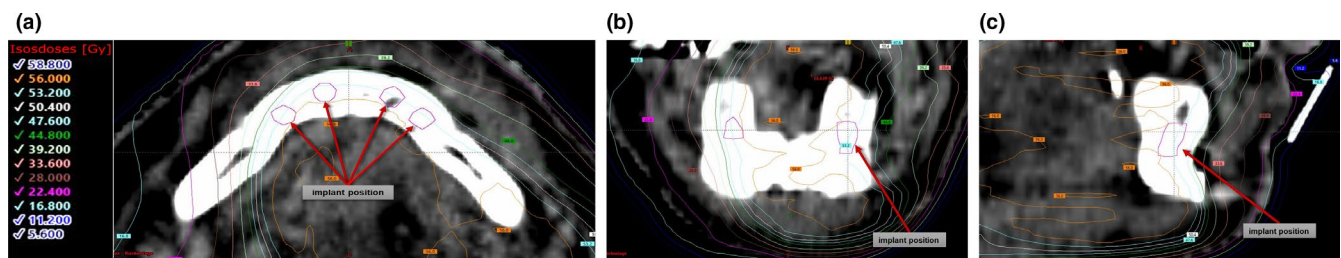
Radiotherapy (RT) planning CT data set matched to the position of the implants (outlined in pink and indicated by the red arrows). (a) Axial view with corresponding RT isodose lines in Gy (box to the left) in the color of their respective field line. (b) Coronal view with corresponding RT isodose lines in Gy. (c) Sagittal view with corresponding RT isodose lines in Gy
